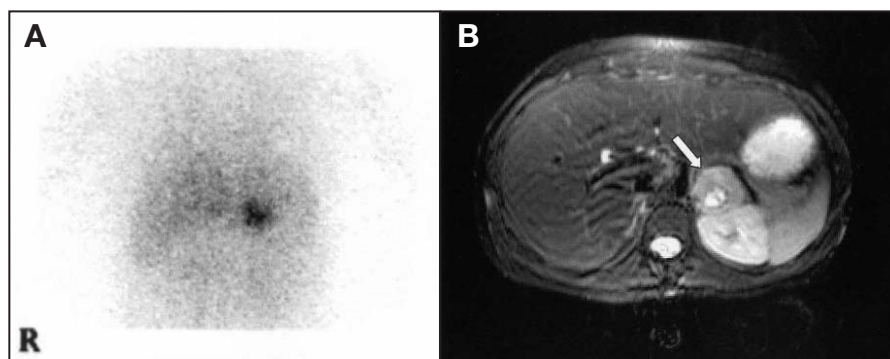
(A) I-131 metaiodobenzylguanidine scan demonstrates increased left suprarenal tracer uptake. (B) T2-weighted axial fat saturated magnetic resonance imaging demonstrates a 3.7-cm T2 signal mass in the expected region of the left adrenal gland, consistent with pheochromocytoma.
